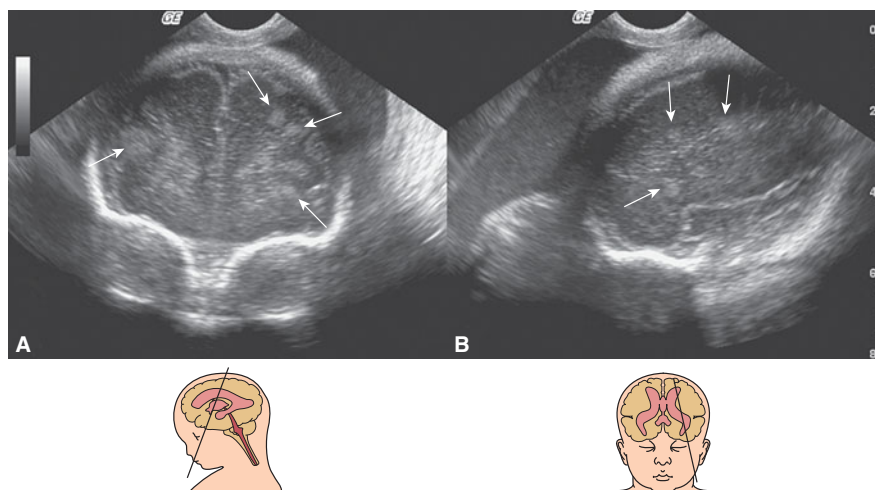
Brain transvaginal sonography (TVS) images in a fetus with tuberous sclerosis at 28 postmenstrual weeks (same patient as in Figure 7-14) show multiple parenchymal echogenic nodules (arrows). (A) Coronal section at the level of the frontal horns. (B) Paramedian section lateral to the lateral ventricle.
